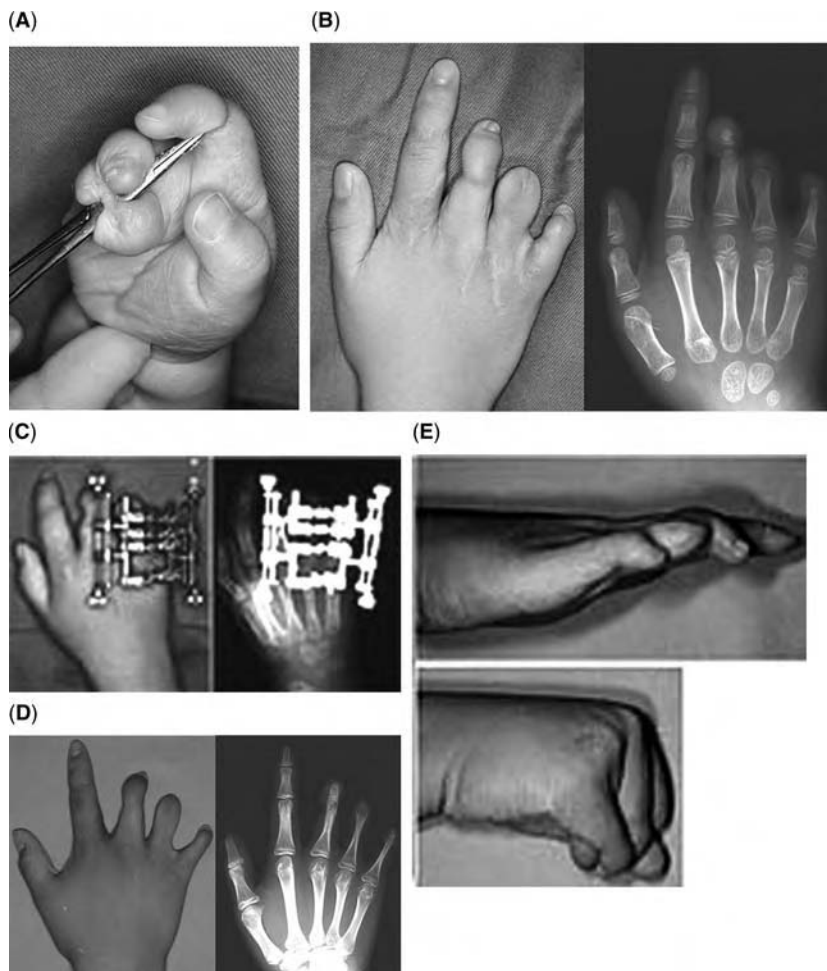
Monolateral technique for lengthening in the case of a five-year-old boy with shortened ring and little fingers due to amniotic band syndrome of the right hand. (A) A photograph of the right hand at six-months-old on the first visit to the clinic. Separation of middle, ring, and little fingers and web plasty were performed when the patient was one year of age. (B) A prelengthening photograph and a radiograph of the right hand. (C) Bone lengthening of ring and little proximal phalanges using the monolateral technique. Apparatus fixation was made across the metacarpophalangeal joints. (D) A photograph and a radiograph of the right hand at 110 months after the lengthening. (E) Grasping action of the right hand. The patient reported that he could grasp larger objects after lengthening. Source: From Ref. 7.
